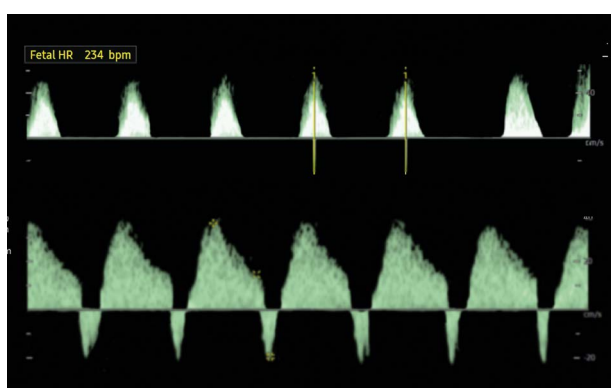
Doppler readings: in the top row, monophasic inflow through the tricuspid valve at a fetal heart rate of 234 bpm; in the bottom row, abnormal flow in the ductus venosus – a deep negative a-wave and significantly reduced D-wave are noticeable
